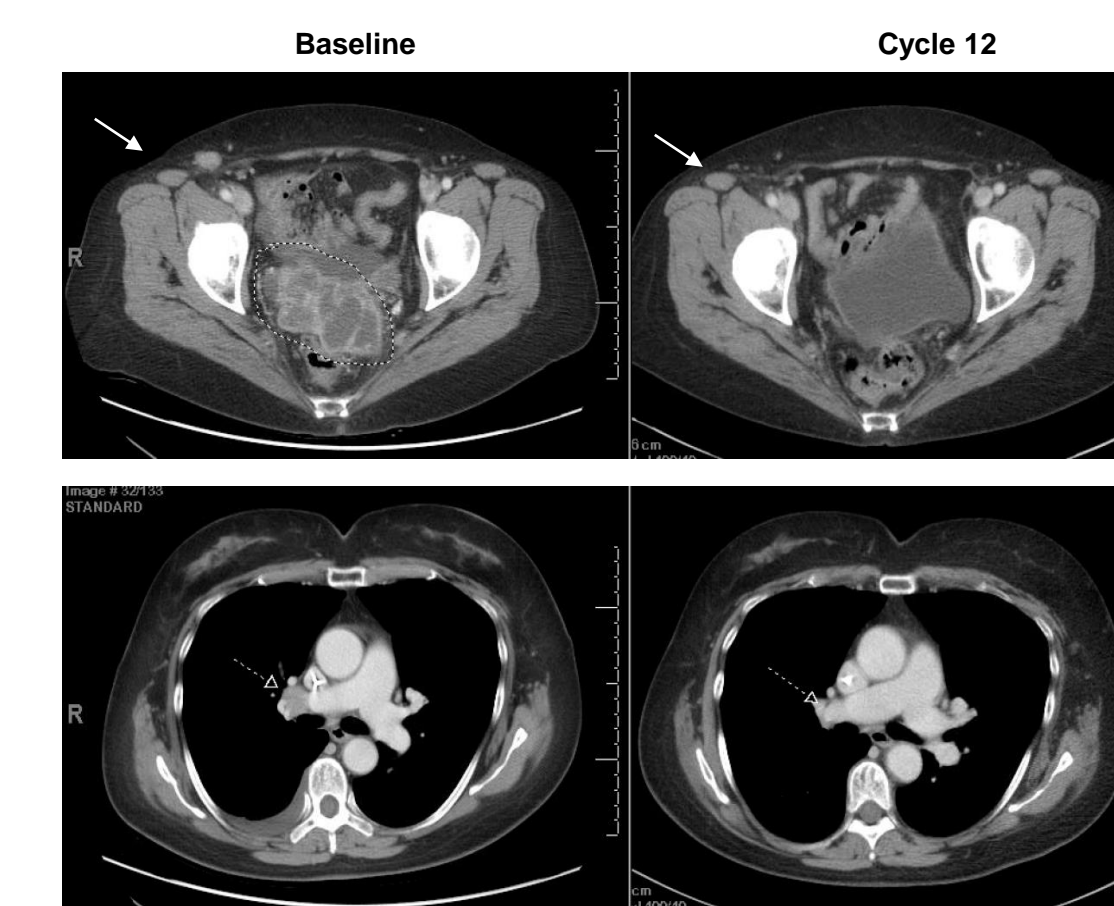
CT Scan of Subject 053-0007 with PR
